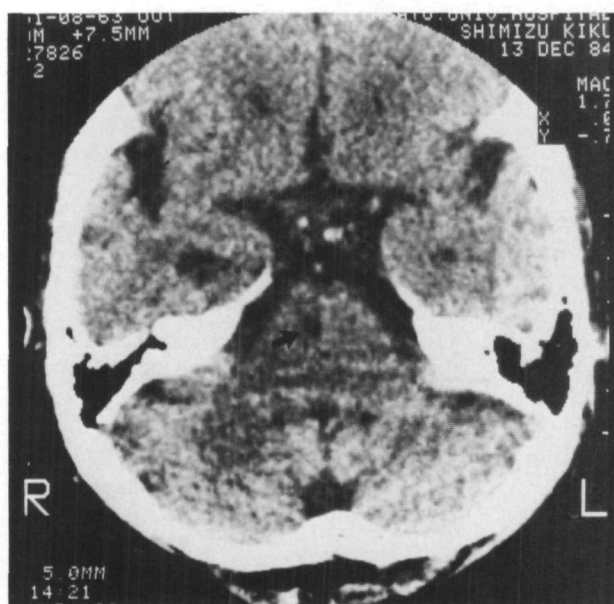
CT scan, three months after onset of left-sided ataxic hemiparesis, shows a low density area in the paramedian portion of the right upper pontine basis (arrow). CT scans during the acute stage were negative.
